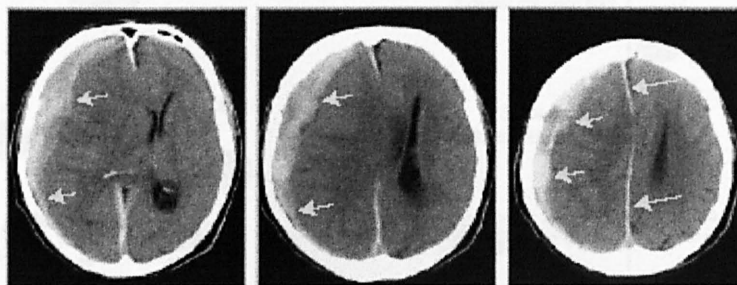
Subsequent CT slices through the brain show a subdural haemorrhage as a hyper dense region along the inner skull wall (short arrows). The blood causes an increased pressure on the brain structures with a displacement of the midsagittal line (long arrows). Extracted from (Suetens, 2001) (p54).
